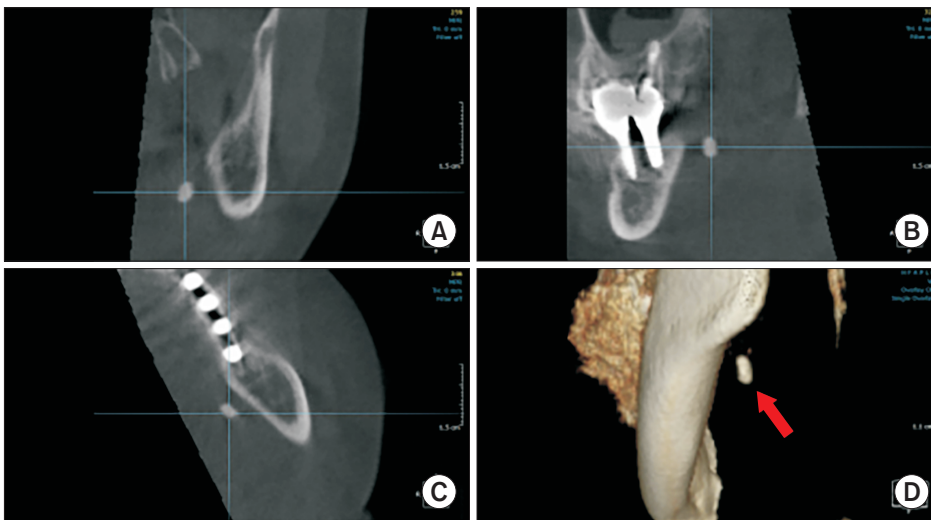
Preoperative computed tomography images and cone-beam computed tomography (CBCT). CBCT images in the (A) coronal, (B) sagittal, and (C) axial planes showing the remnant root tip. D. A posterior view of the skull highlighting the residual root (arrow) in the left sublingual area.
